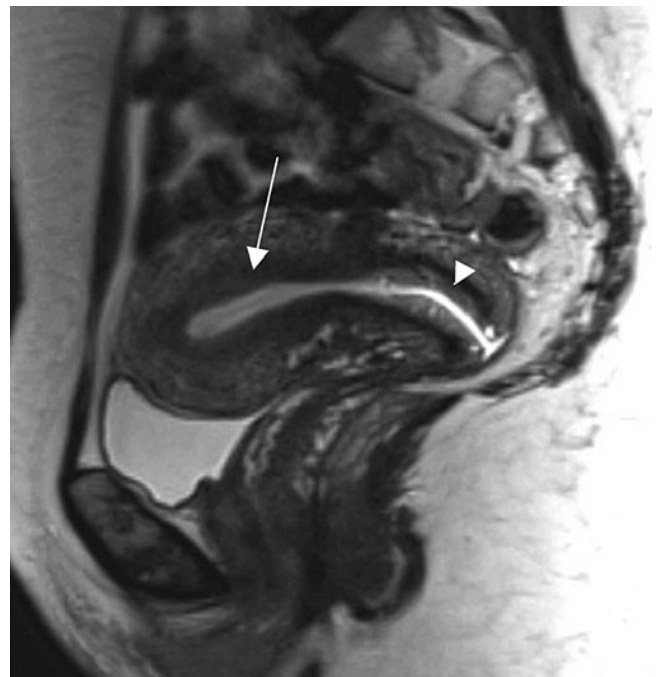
Normal magnetic resonance imaging (MRI) of the uterine anatomy on sagittal 3D T2-weighted multiplanar reconstruction (MPR) of the uterus and cervix demonstrates normal zonal anatomy. There are three zones identifiable in the uterus: hyperintense endometrium, hypointense junctional zone (*arrow*), and intermediate signal intensity of the outer myometrium. Four zones are distinguished in the cervix: hyperintense mucus within the endocervical canal, hypointense cervical stroma, and intermediate signal intensity of the outer smooth muscle
